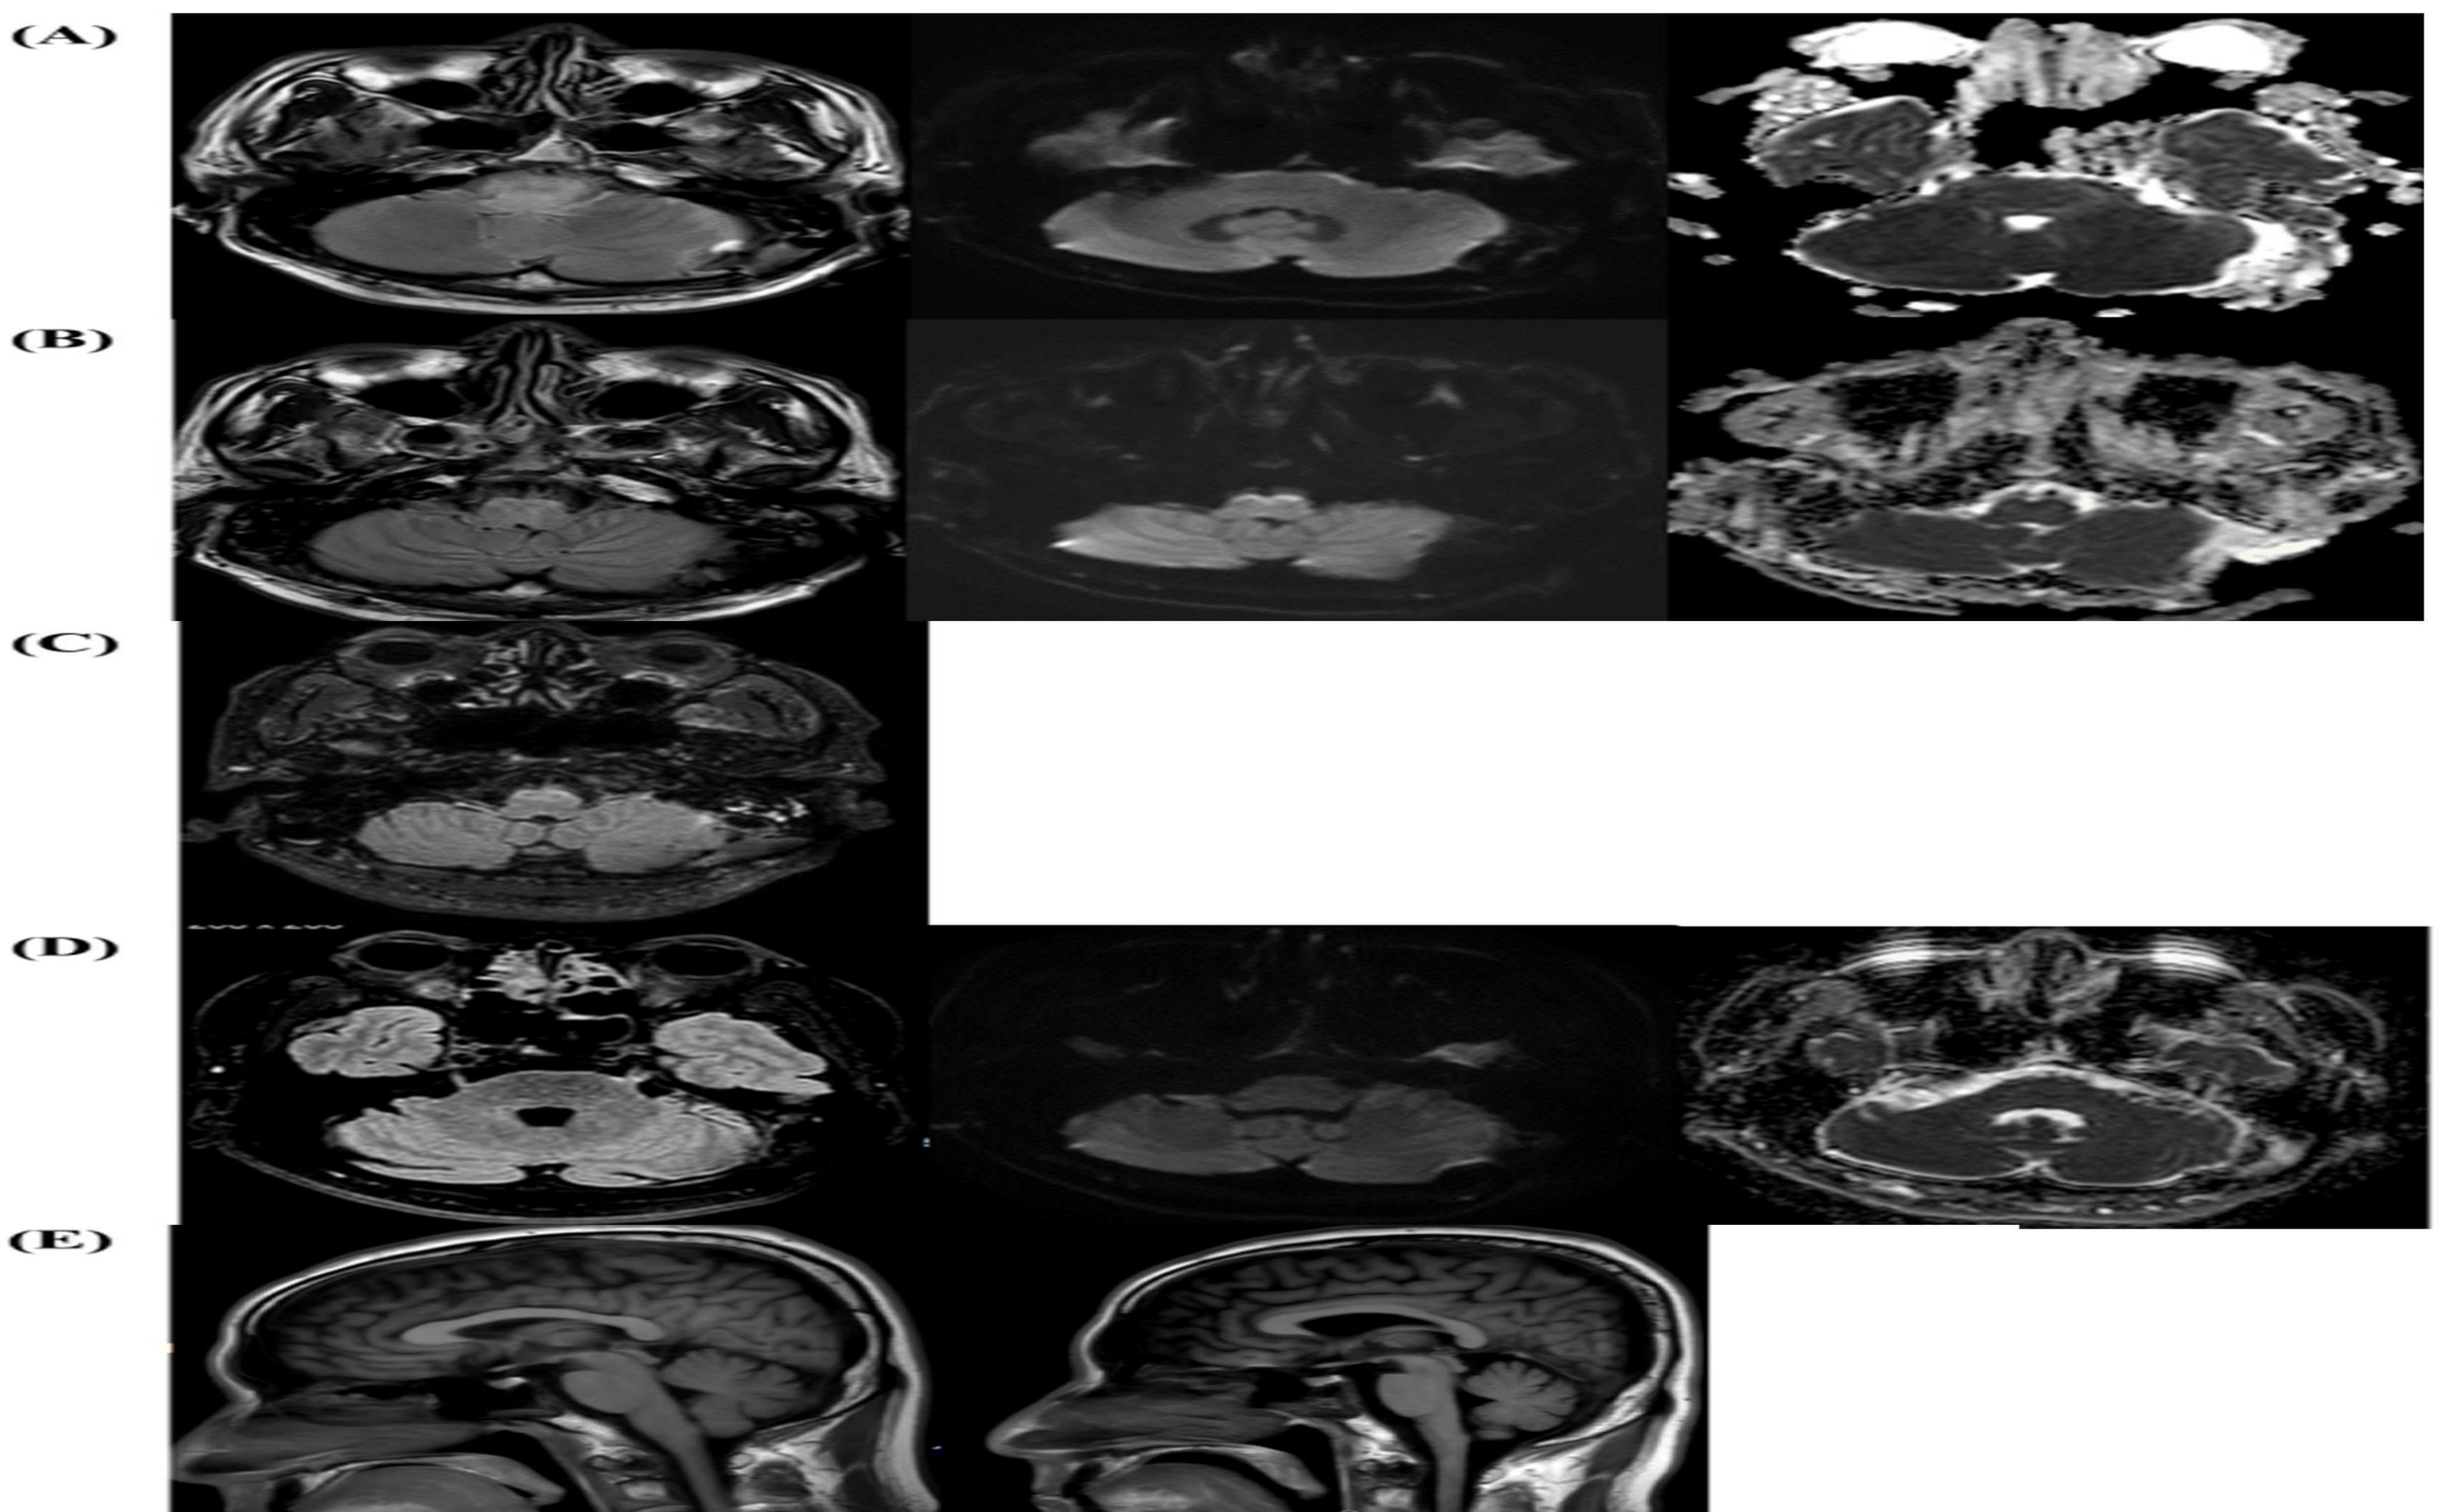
Evolution of brainstem injury following microvascular decompression. Axial panels (A–D): T2-FLAIR, DWI, ADC sequence. Panel (E): midline T1-weighted sagittal images. (A) POD 0: Ventral medullary/pontine T2-FLAIR hyperintensity without diffusion restriction (vasogenic edema). (B) POD 8: New diffusion-restricted lesions in anterior medulla and lower pons with ADC hypointensity (cytotoxic injury). (C) POD 65: Bilateral anterior medullary T2-FLAIR hyperintensity (subacute inflammation). (D) POD 268: Improvement of FLAIR hyperintense changes. (E) Preoperative vs POD 268: Pronounced medullary atrophy with thinning and expansion of pre-medullary CSF space.
